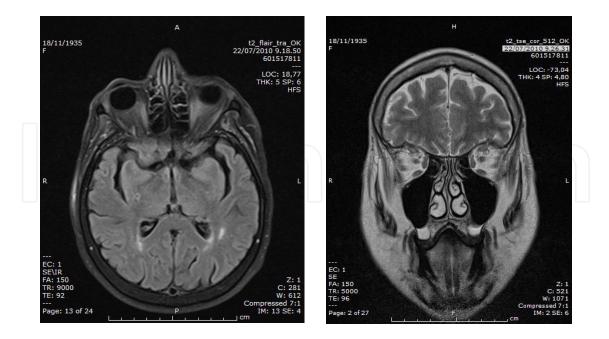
MRI brain scan (FLAIR and T2 sequences) of a 75 old woman with progressive FTD with mainly behavioural disturbances showing frontal and temporal lobe atrophy along with minor periventricular hyperintensities. She had deficit in executive and attention functions, aggressive behaviour and obsessive-compulsive disorder.
